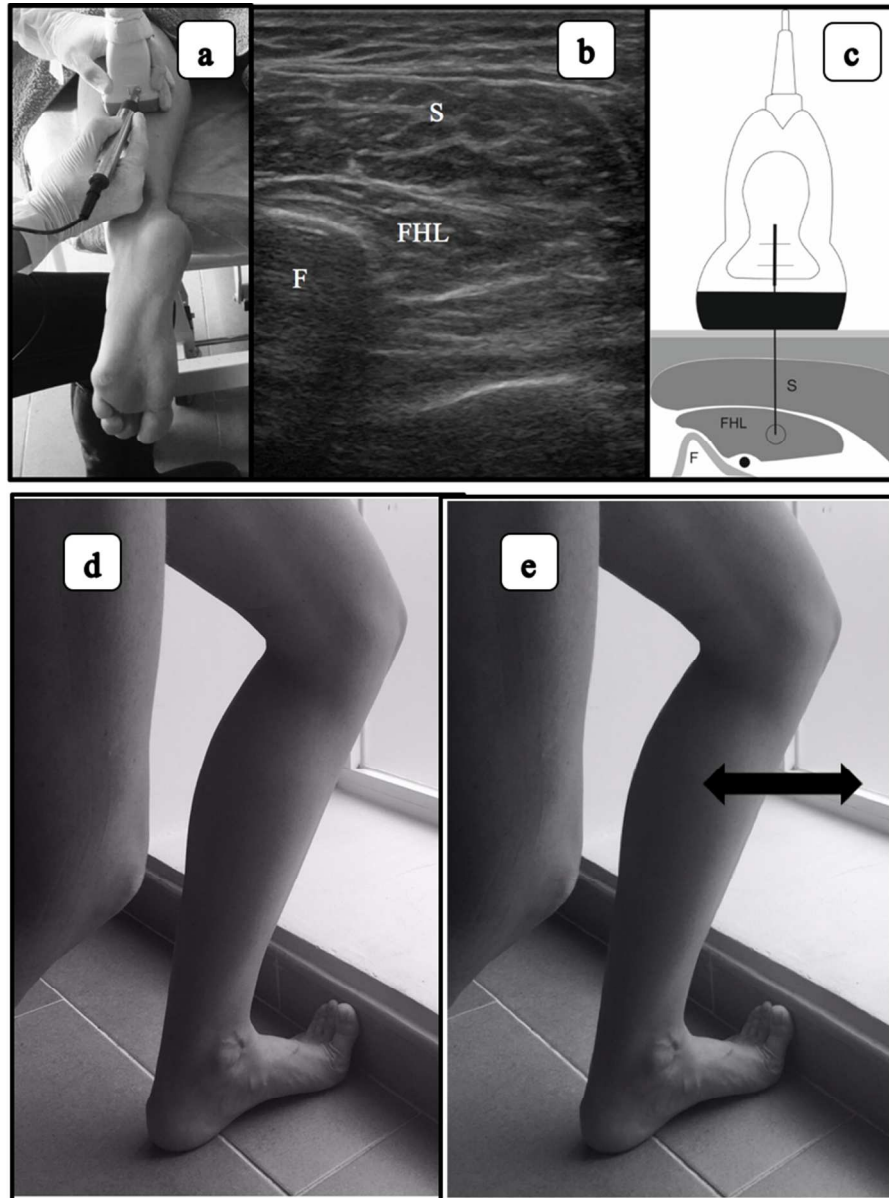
a) Ultrasound-guided PNM intervention in FHL muscle; b) ultrasound image of the intervention. FHL: Flexor Hallucis Longus muscle; S: soleus muscle, F: Fibula; and c) ultrasound-guided of invasive approach of FHL muscle; d) Static stretching exercise of FHL muscle; e) Eccentric exercise of FHL muscle.
